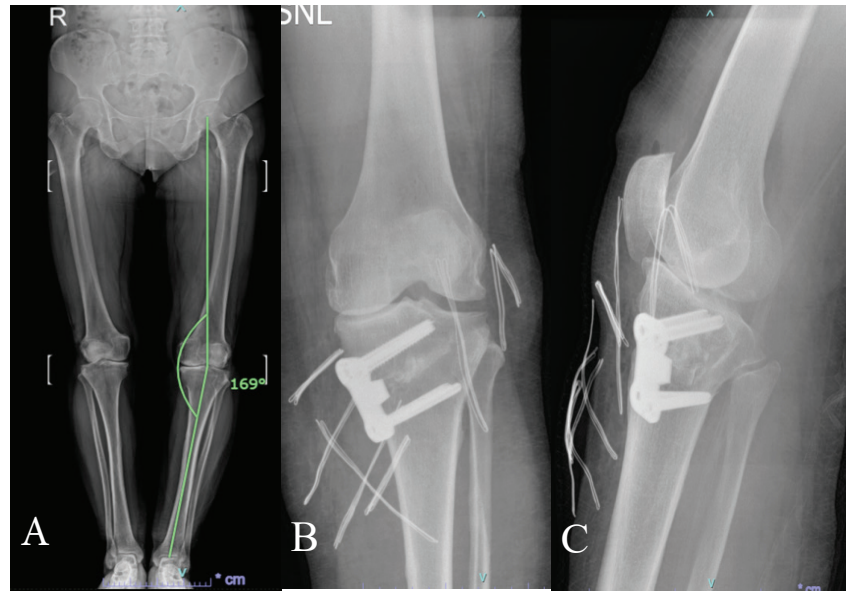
A) axis B) anterior-posterior C) lateral radiographs of the patient who underwent HTO on the left knee
